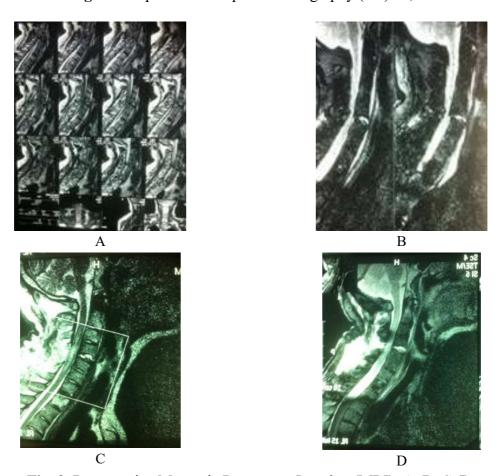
Preoperative Magnetic Resonance Imaging (MRI): A, B, C, D.
